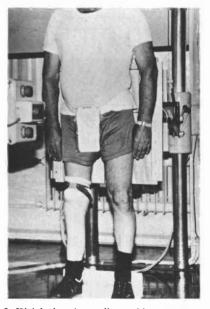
Weight bearing radiographic measurement of the discrepancy between the length of lower limb prosthesis and contralateral lower extremity.
